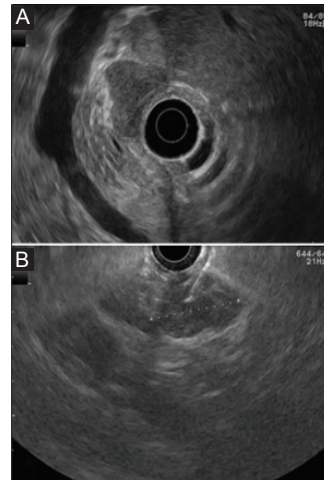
(A) Hypoechoic, triangular, homogeneous, grayish mass evoking an inflammatory enlargement of lymph node mass between the pancreas and the duodenal wall. (B) Endoscopic ultrasound fine needle aspiration biopsy of the lesion
